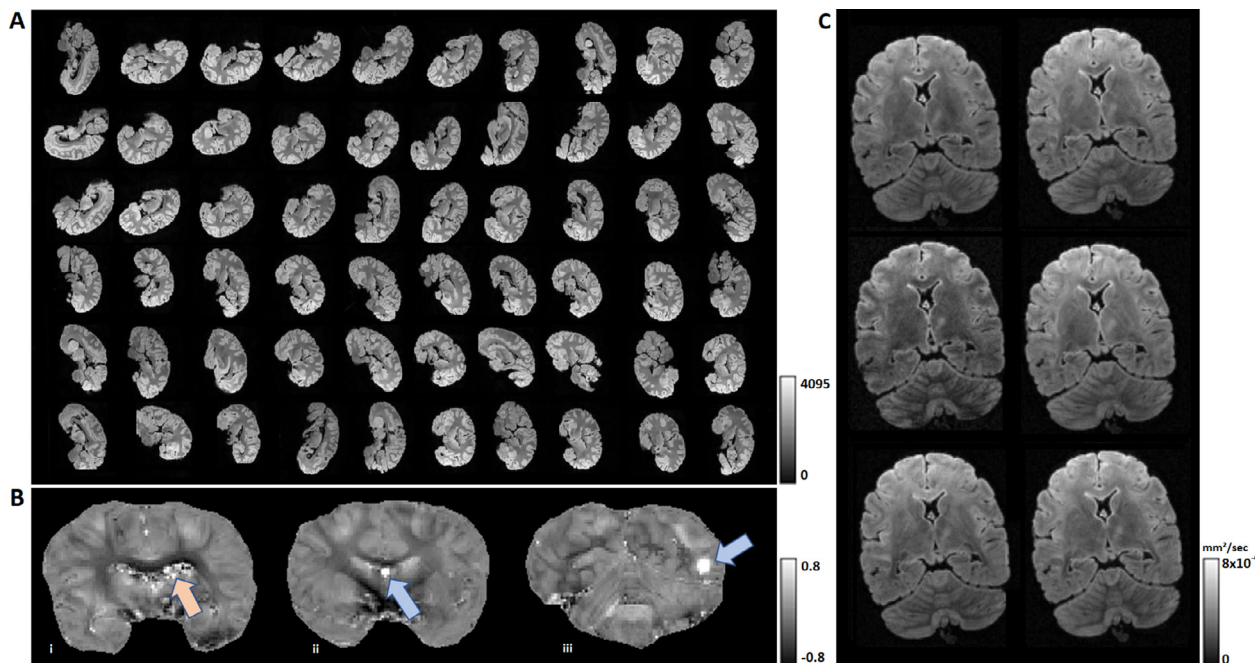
(A) Demonstration of the magnitude image quality obtained at TE=29.48 ms in 61 consecutive GRE acquisitions with reorientation of the sample (center slice of each individual dataset). (B) Local phase images at the reference orientation indicating artifacts related to remaining small air bubbles within the cavity of the left lateral ventricle (left; orange arrow) as well as at two other positions (middle and right; blue arrows). (C) Examples of images obtained at different directions of the diffusion-weighting gradient for demonstration of the data quality of the DWI experiment.
